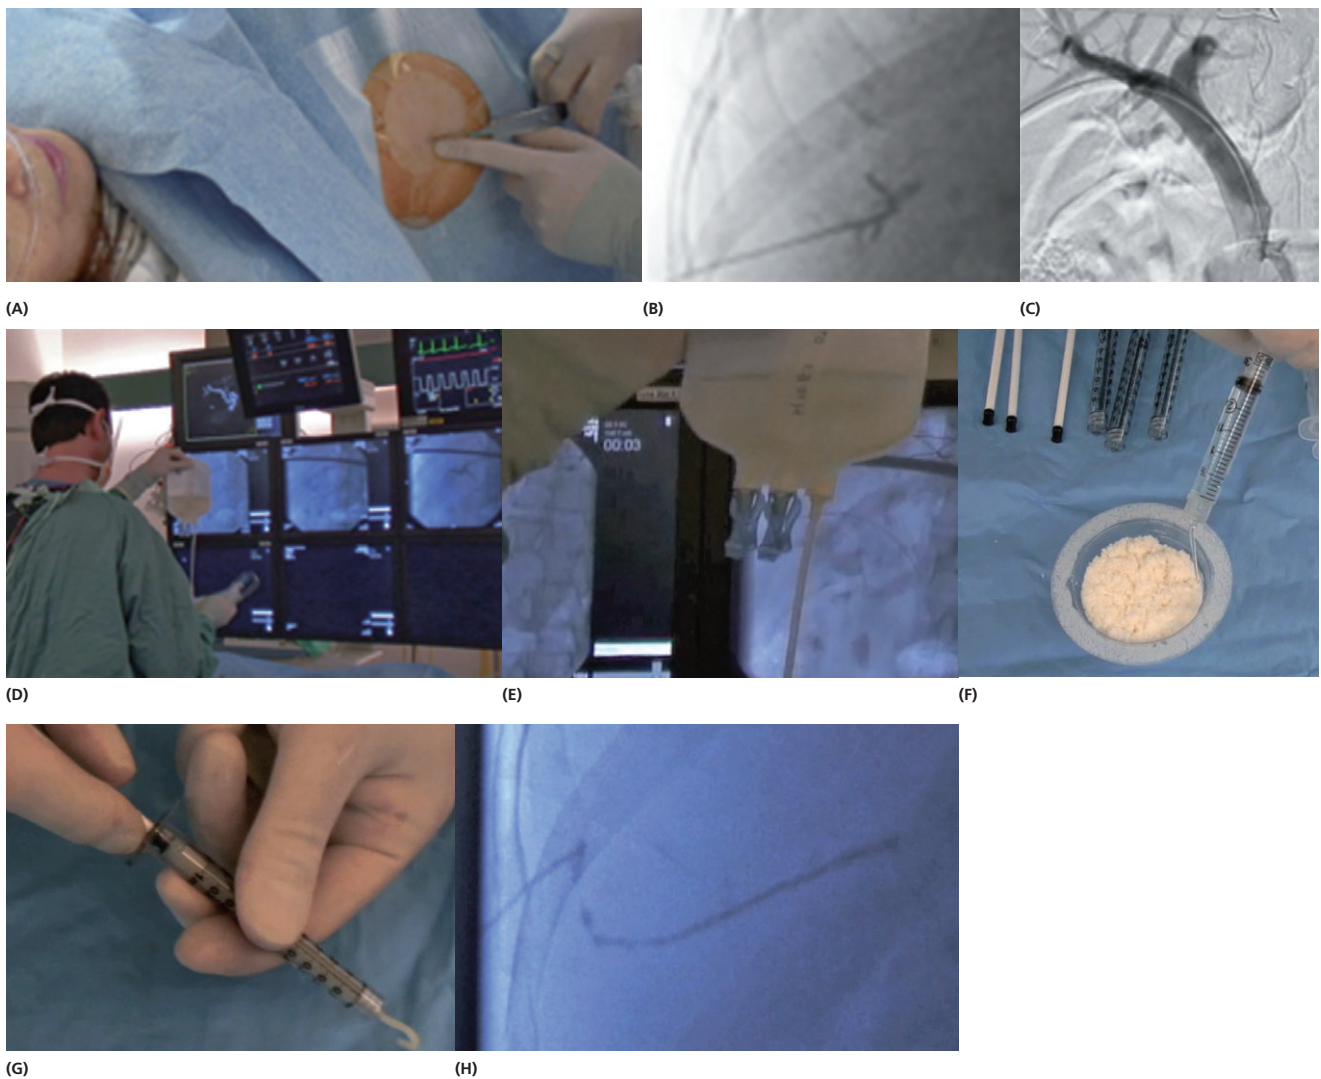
Steps involved with percutaneous islet transplantation via an ultrasound-guided fluoroscopic approach: (A) Doppler ultrasound interrogation followed by local anesthesia; (B) direct puncture of a peripheral second or third-order right-sided branch of the portal vein, with recognition of the branching pattern on fluoroscopy; (C) portal angiogram with the tip of a 4 or 5 French catheter at the portomesenteric splenic junction; (D) islet infusion under gravity after addition of 70 U/kg (based on recipient weight) heparin to the islet bag, with intermittent direct monitoring of portal pressure; (E) close-up of the i.v. tubing with transplant tissue visible; (F) making up microfibrillary collagen paste (Avitene) with 1 g powder and 3 mL saline and 3 mL radiological contrast media; (G) loading the paste in a 1-mL syringe; (H) obliteration of the catheter tract for a minimal length of 4 cm, under direct fluoroscopic visualization.
